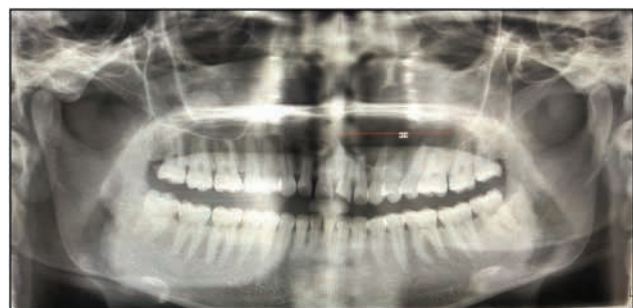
Panoramic radiograph showing extension into the antrum
